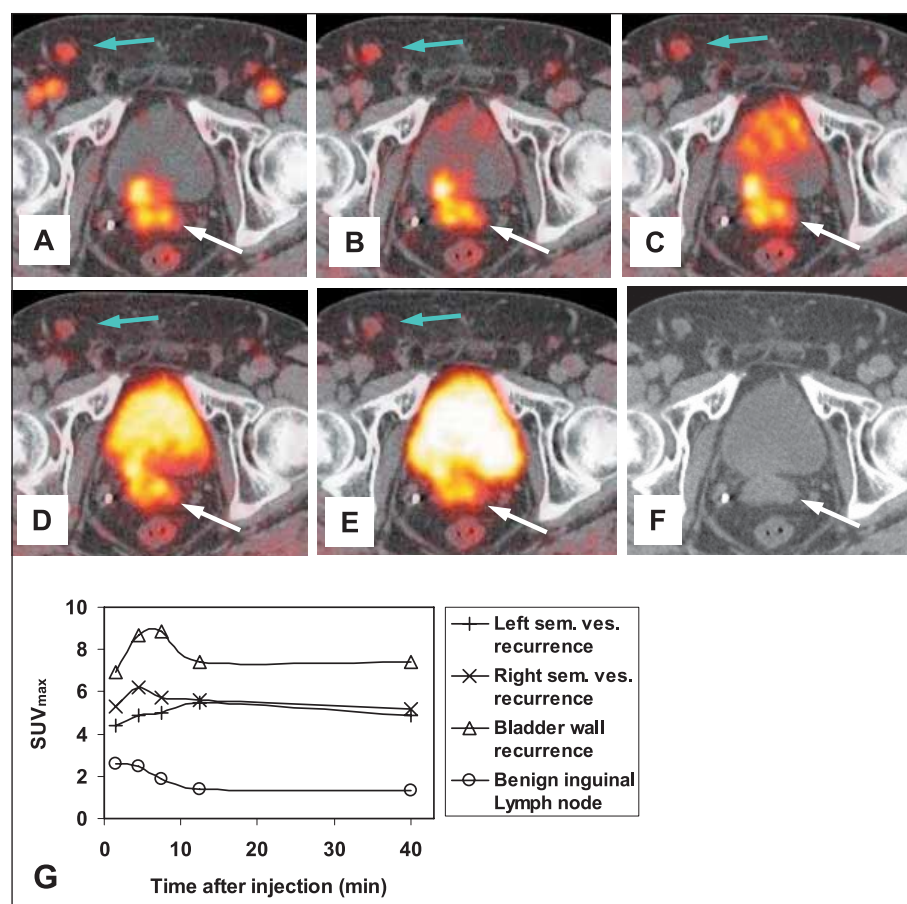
Three-phase PET/CT display showing dynamic frames A (0–3 min), B (3–6 min) and C (6–9 min post injection), followed by whole body PET (D, 11–14 min p. i.) and delayed scanning (E, ~40 min p. i.), all fused to the initial CT (F). Sequential disappearance of vascular activity (frame A) and appearance of urinary activity (frame C) is observed. Note the differential uptake evolution in suspected cancer lesions (←) compared with the lymph node interpreted as benign (blue arrow) shown below graphically (G).
